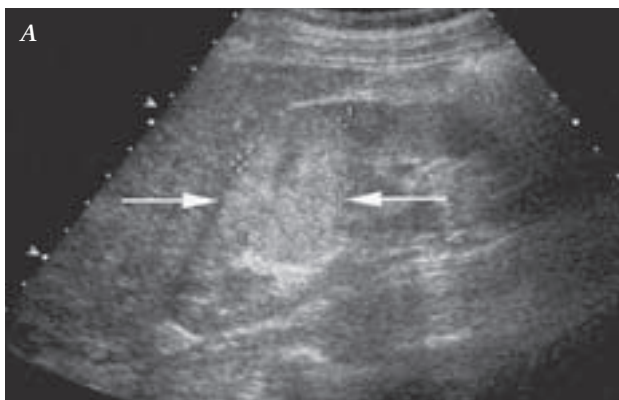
A patient with renal cell carcinoma of the clear cell type. (A): Grayscale ultrasound image shows a homogeneous solid lesion (arrows). (B): Color Doppler ultrasound image shows marked tumor vascularity (arrows).
